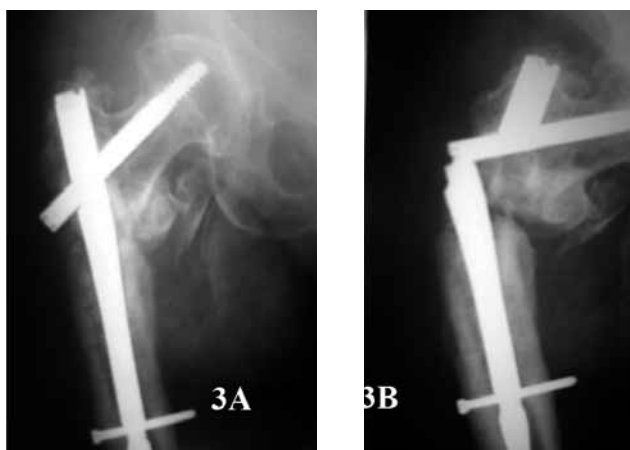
A – postoperative radiograph of second Gamma 3 nail locked in static mode distally. Main fragments still distracted. Posteromedial wall deficiency filled with bone allograft. B – signs of bone non-union and renewed failure of the nail at the aperture of the lag screw, 7 months after surgery.
